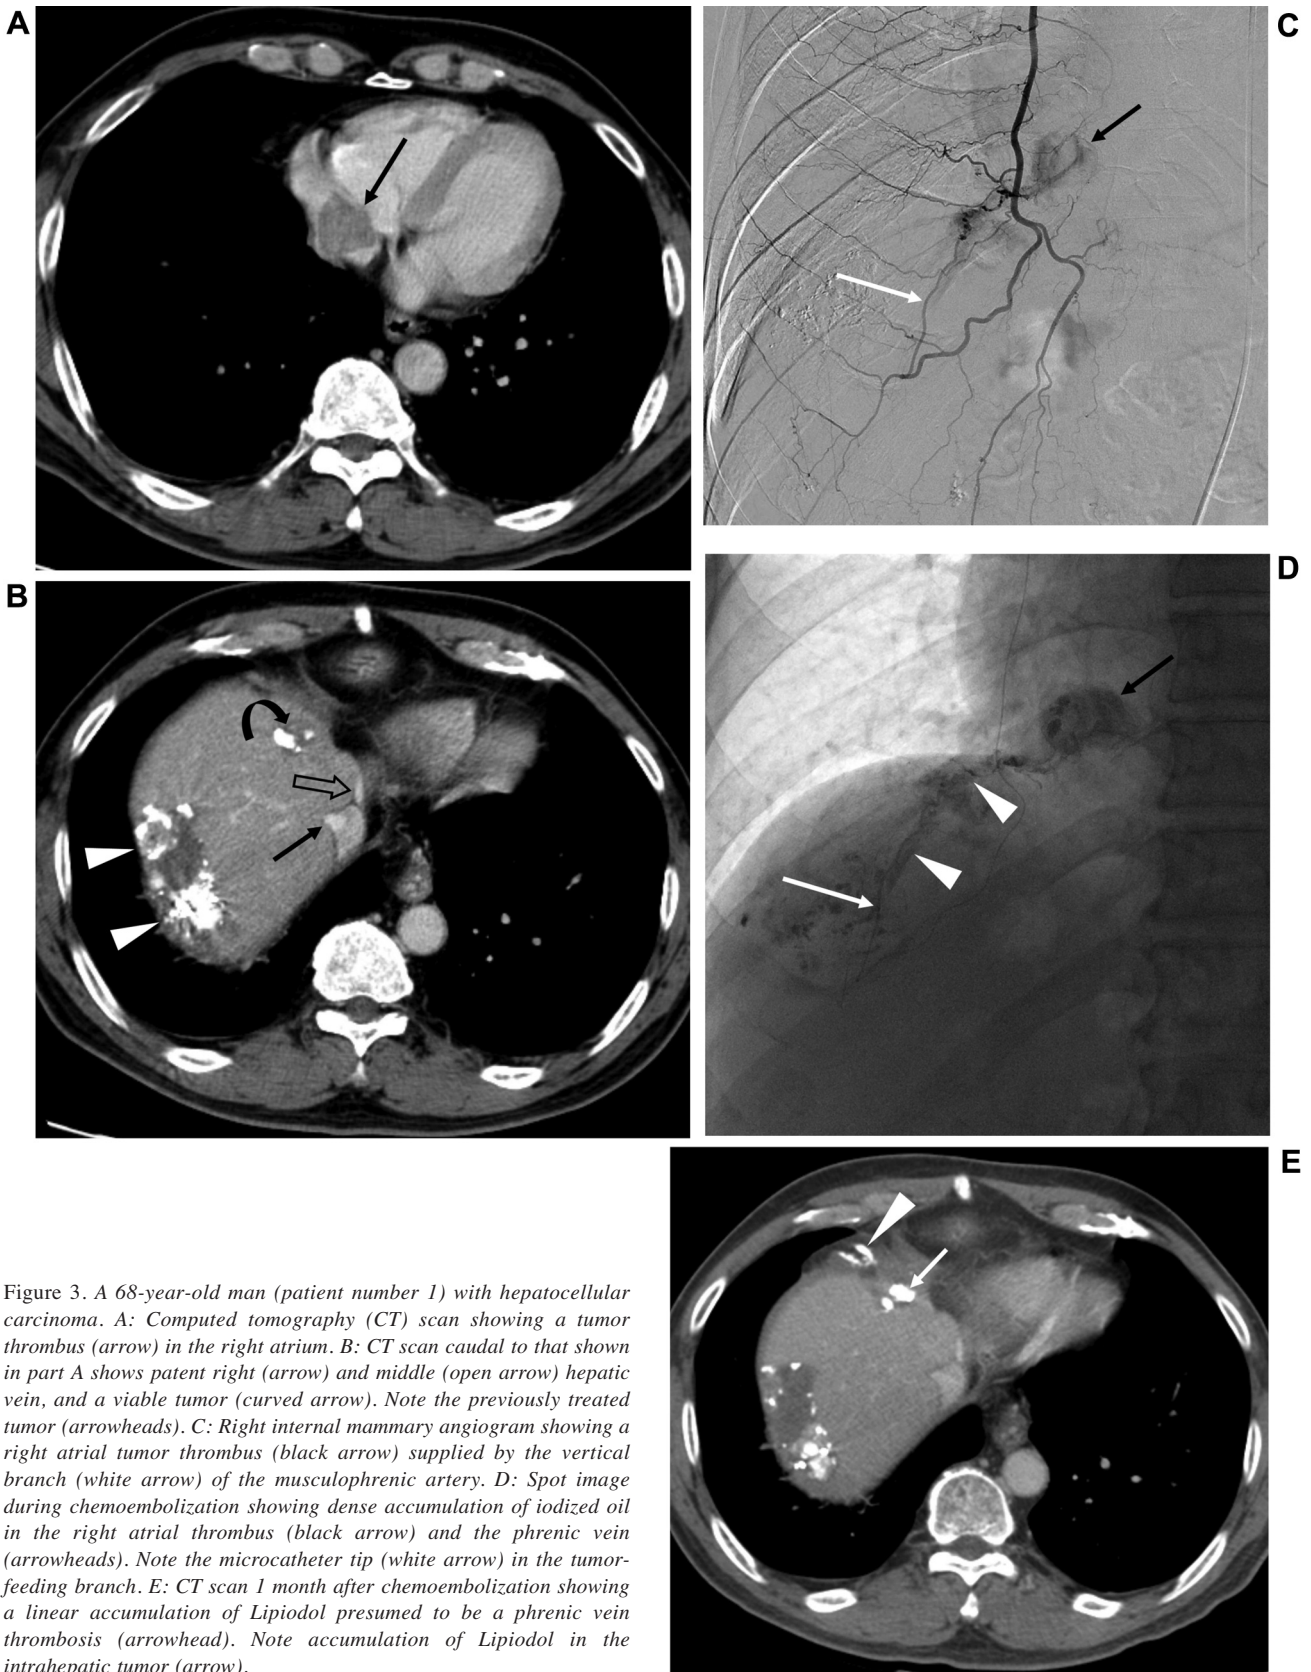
A 68-year-old man (patient number 1) with hepatocellular carcinoma. A: Computed tomography (CT) scan showing a tumor thrombus (arrow) in the right atrium. B: CT scan caudal to that shown in part A shows patent right (arrow) and middle (open arrow) hepatic vein, and a viable tumor (curved arrow). Note the previously treated tumor (arrowheads). C: Right internal mammary angiogram showing a right atrial tumor thrombus (black arrow) supplied by the vertical branch (white arrow) of the musculophrenic artery. D: Spot image during chemoembolization showing dense accumulation of iodized oil in the right atrial thrombus (black arrow) and the phrenic vein (arrowheads). Note the microcatheter tip (white arrow) in the tumor-feeding branch. E: CT scan 1 month after chemoembolization showing a linear accumulation of Lipiodol presumed to be a phrenic vein thrombosis (arrowhead). Note accumulation of Lipiodol in the intrahepatic tumor (arrow).
